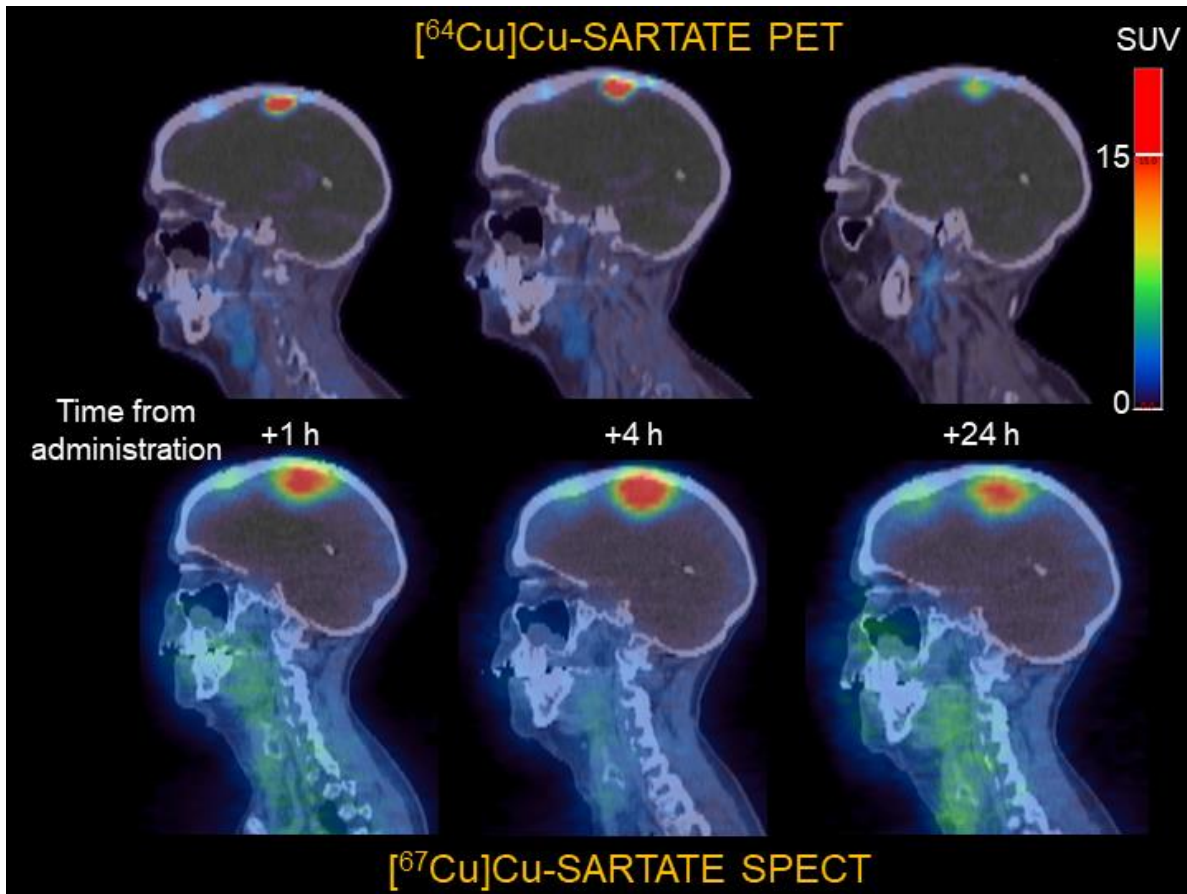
The reproducibility of the copper theranostic PET and SPECT pairing is shown in this comparison of SARTATE where targeting of the two compounds using PET and SPECT at equivalent time points after administration are shown. The change of radionuclide from copper-64 to copper-67 does not alter the targeting to the tumour in this subject. The SPECT images are from cycle 1 of treatment. The volume of the main lesion in the SPECT images appears greater than in the PET images due to the poorer spatial resolution of SPECT. The PET images are shown at a fixed SUV upper threshold (max = 15) while the SPECT images are shown with individual scaling. The 96 h SPECT time point has been omitted as there was no comparable PET image.
